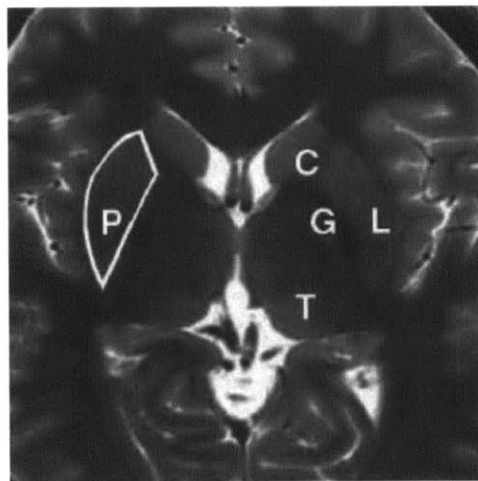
Axial T2-weighted MR image of basal ganglia anatomy
